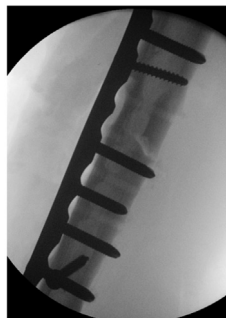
Radiograph: image intensifier - ORIF.
